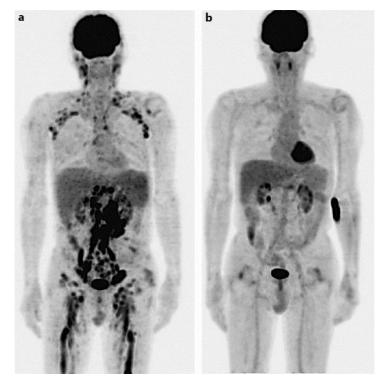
¹⁸F-FDG-PET images at relapse (a) and 507 days after RIC-HSCT (b). Multiple indications of abnormal ¹⁸F-FDG uptake (a) disappeared after RIC-HSCT.
